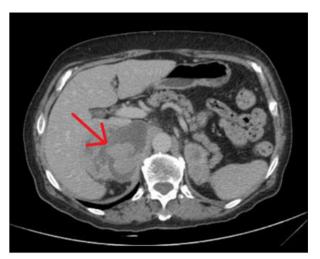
CT scan. Staging CT scan showing a large adrenal metastasis (indicated by the red arrow).
